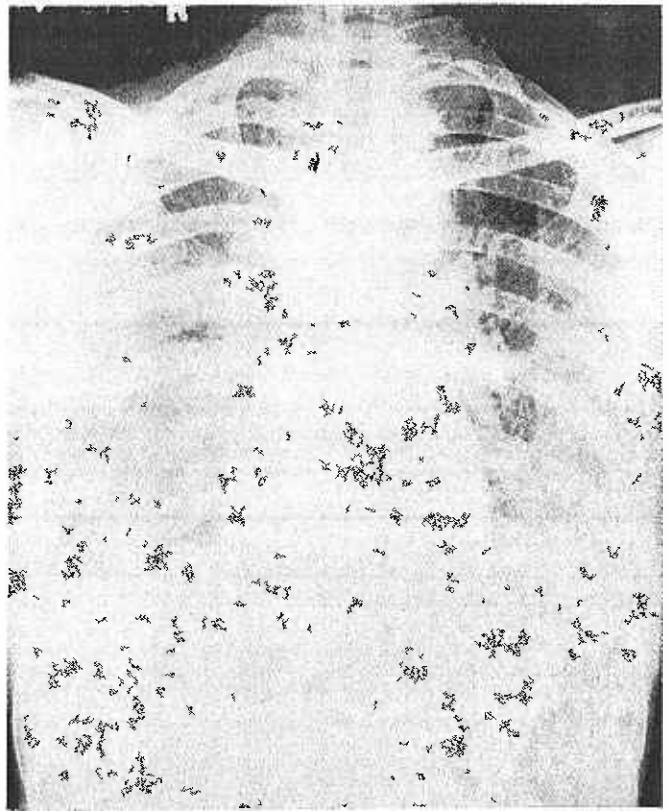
Chest radiograph taken on 6th October 1970 shows diffuse mottling over both lung fields.
